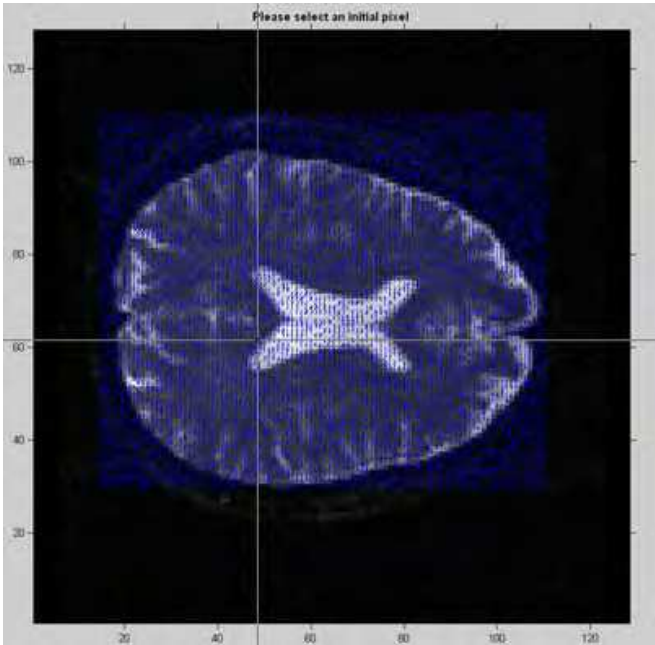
Eigenvectors of the whole slice is represented on the registered anatomic MR image. The manually executed seed point selection is seen on the figure.
